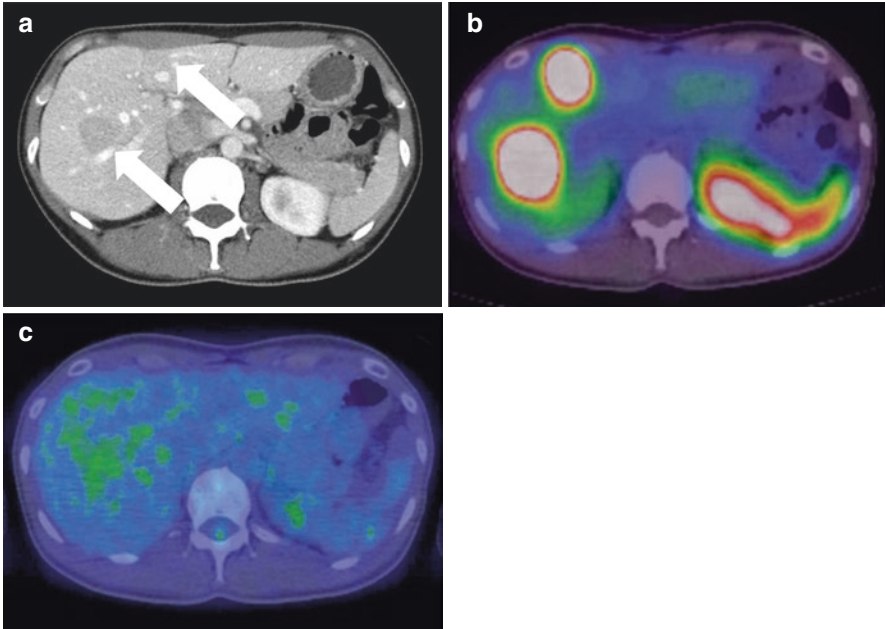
A 30s' female with multiple liver metastases from G2 NET originated in the small intestine. (a) A contrast-enhanced CT image depicts poorly enhanced lesions in the right hepatic lobe (arrows). (b) Somatostatin receptor scintigraphy (SRS) (24 h after the injection) reveals strong expression of receptors on these lesions, indicating that lesions are well-differentiated. (c) An FDG/PET fusion image shows faint uptake in these lesions, suggesting their low metabolic activity
